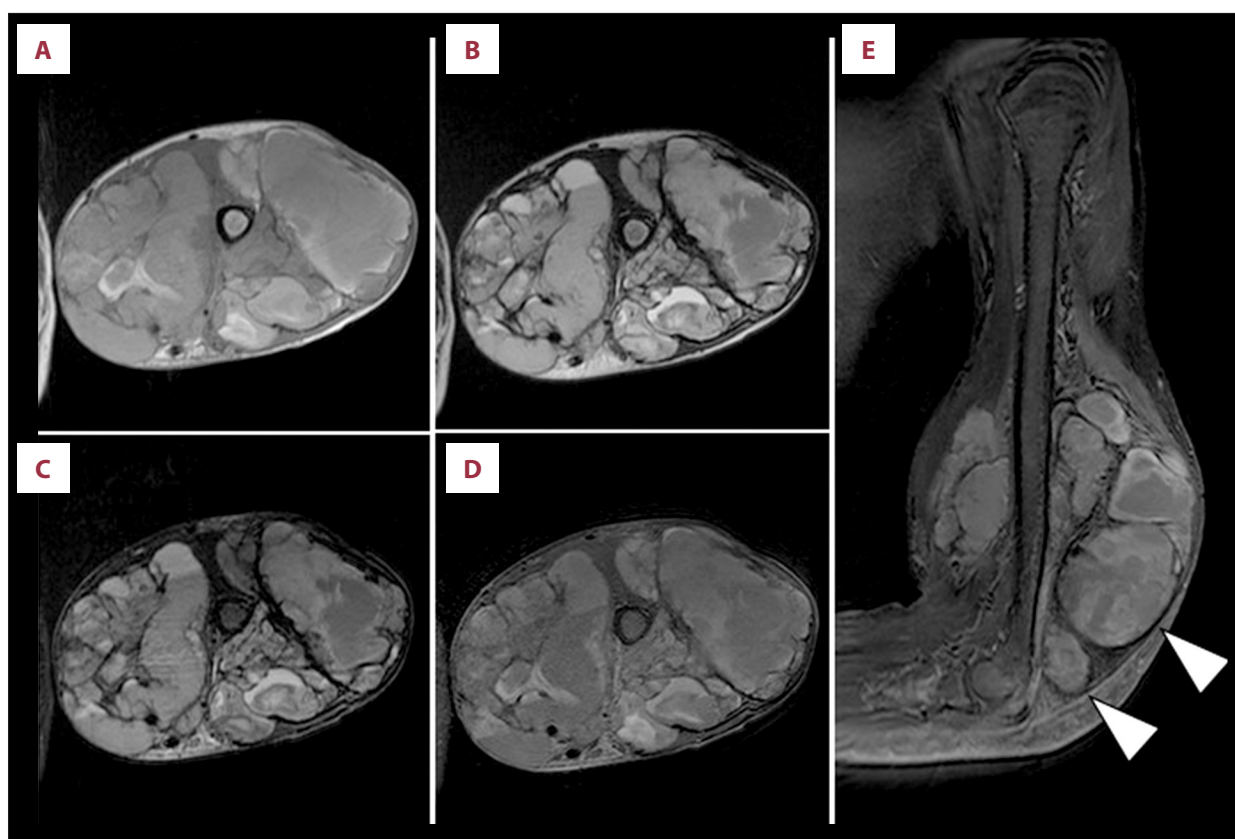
Magnetic resonance imaging (MRI) findings at the re-presentation. MRI shows a multilocular cystic lesion measuring approximately $15.0 \times 17.6 \times 10.0$ cm in the distal portion of the left upper arm. The lesion has iso-to-high-signal intensity on T1-weighted images (A, axial), and slightly low-signal intensity on T2-weighted images (B, axial) and short tau inversion recovery images (C, axial). Gadolinium-enhanced MRI shows solid components with contrast enhancement adjacent to the cystic lesion (arrowheads) (D, axial; E, sagittal).
